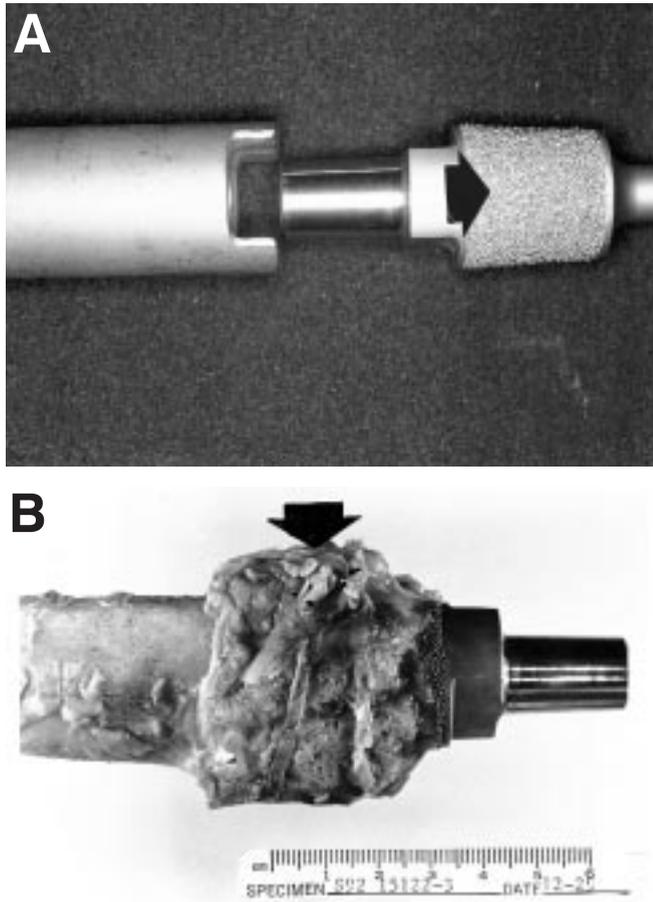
Extracortical fixation of a distal femoral prosthesis. (A) Close-up of the taper of the Modular Replacement System (Howmedica, Inc., Rutherford NJ). Note the porous coating of the body of the stem (arrow). (B) Autopsy retrieval of distal femoral prosthesis. The bone graft (arrow) is well fixed to the porous coating. Note the beads are hardly visible. The Dacron (3 mm) tape is intact and is utilized to fix the autogenous bone graft to the porous-coated segment of the prosthesis. Note there is no evidence of corrosion of the taper. This prosthesis was in for 5 years. (C) Typical radiographic view of extracortical bone fixation (arrow) from the host bone to the porous-coated segment of a custom prosthesis. This is approximately 4 years since implantation. Extracortical bone fixation was first developed as a practical concept following the introduction of porous coating by Howmedica (Rutherford, NJ) during the early 1980s.
